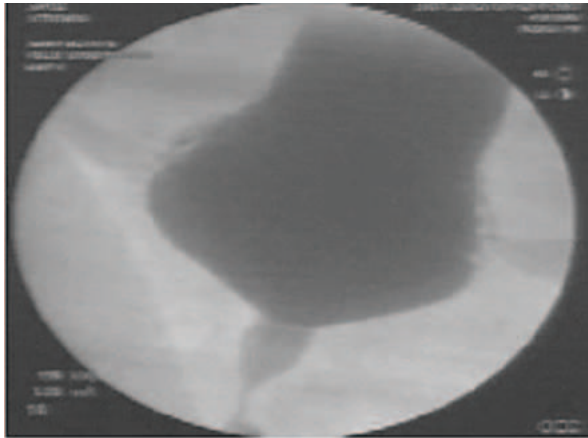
X-ray during voiding(3)
